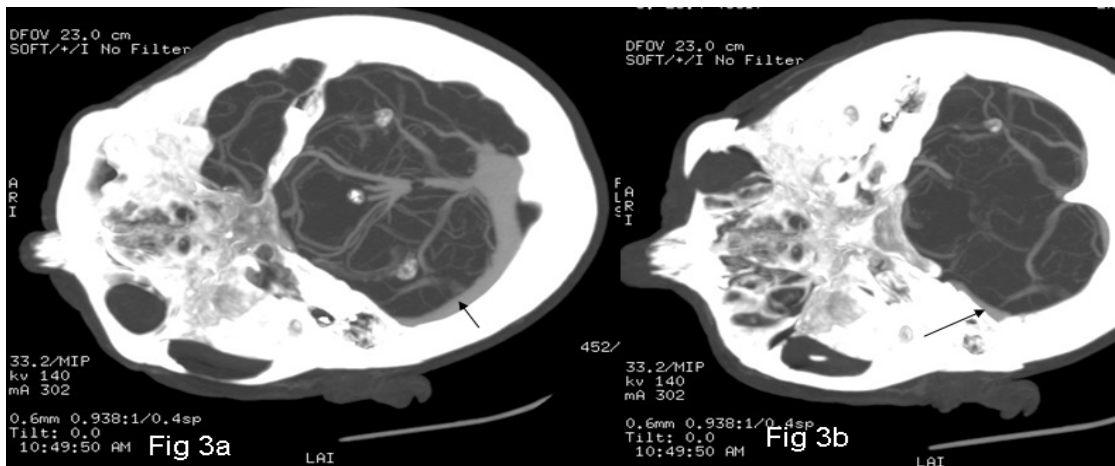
Axial CT venogram study confirms thrombus in the right superior petrosal sinus (short white arrow).
